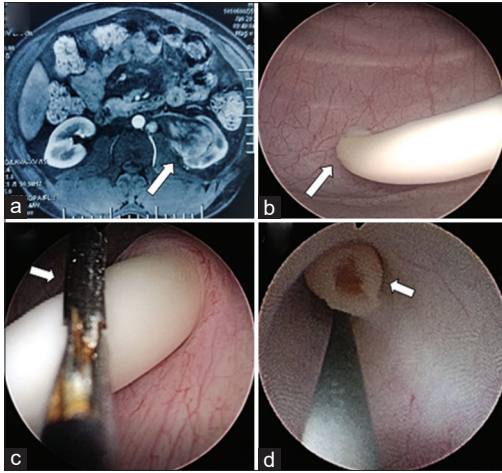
(a) Magnetic resonance imaging scan with gadolinium contrast showing a hypo-enhancing lesion in the left renal pelvis with preserved renal contour (white arrow). (b) A tubular tissue projecting from the left ureteric orifice resembling a double J stent (white arrow). (c) The stent removal forceps were used to extract the clot (white arrow). (d) Ureteroscopy showing the proximal extension of the clot (white arrow) with normal surrounding ureteral mucosa
